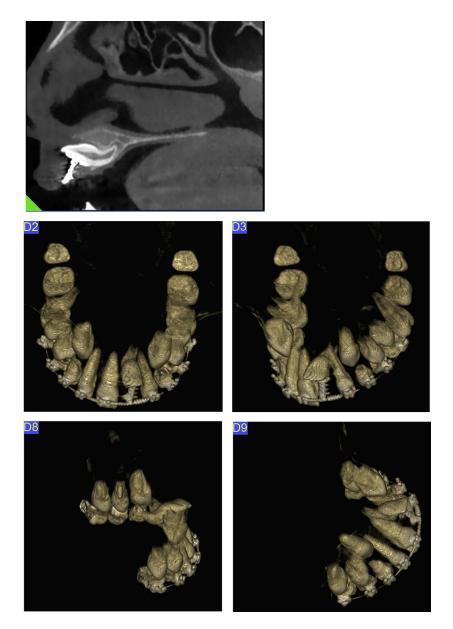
A, CBCT showing the short root of the impacted incisor. B and C, The apical third of the root was curved upwards in proximity to the palatal cortical bone (100° crown-root angle). D and E, Note the contact between the impacted incisor and the maxillary left lateral incisor.
